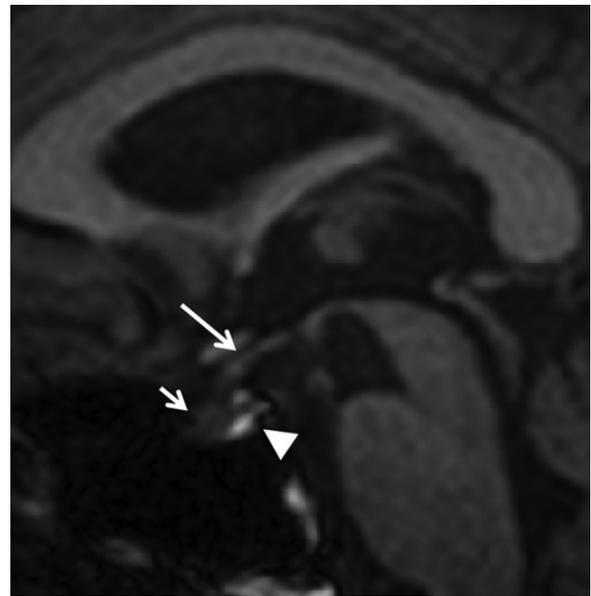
T1-weighted MRI of the pituitary gland showing enlarged infundibulum (long arrow), anterior lobe (short arrow), and posterior lobe from a 57yo patient with SBMA [reproduced from Pieper et al. *Am J Neuroradiol* 2013, permission received].
